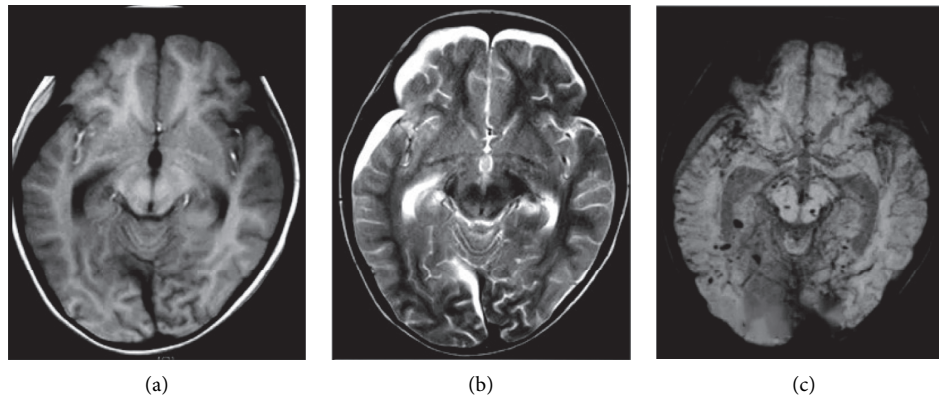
MRI images for craniocerebral injury. (a) T1WI; (b) T2WI; (c) SWI.
